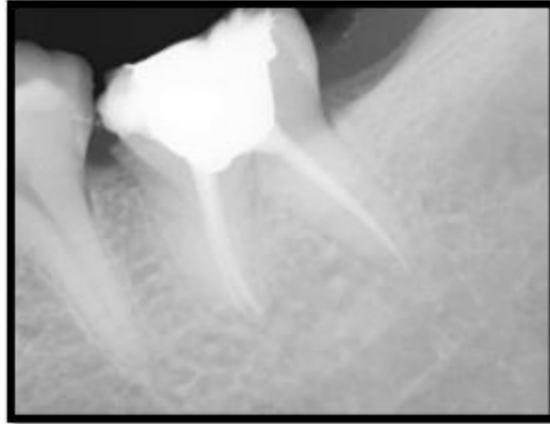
Radiograph showing post endodontic restoration of #37
